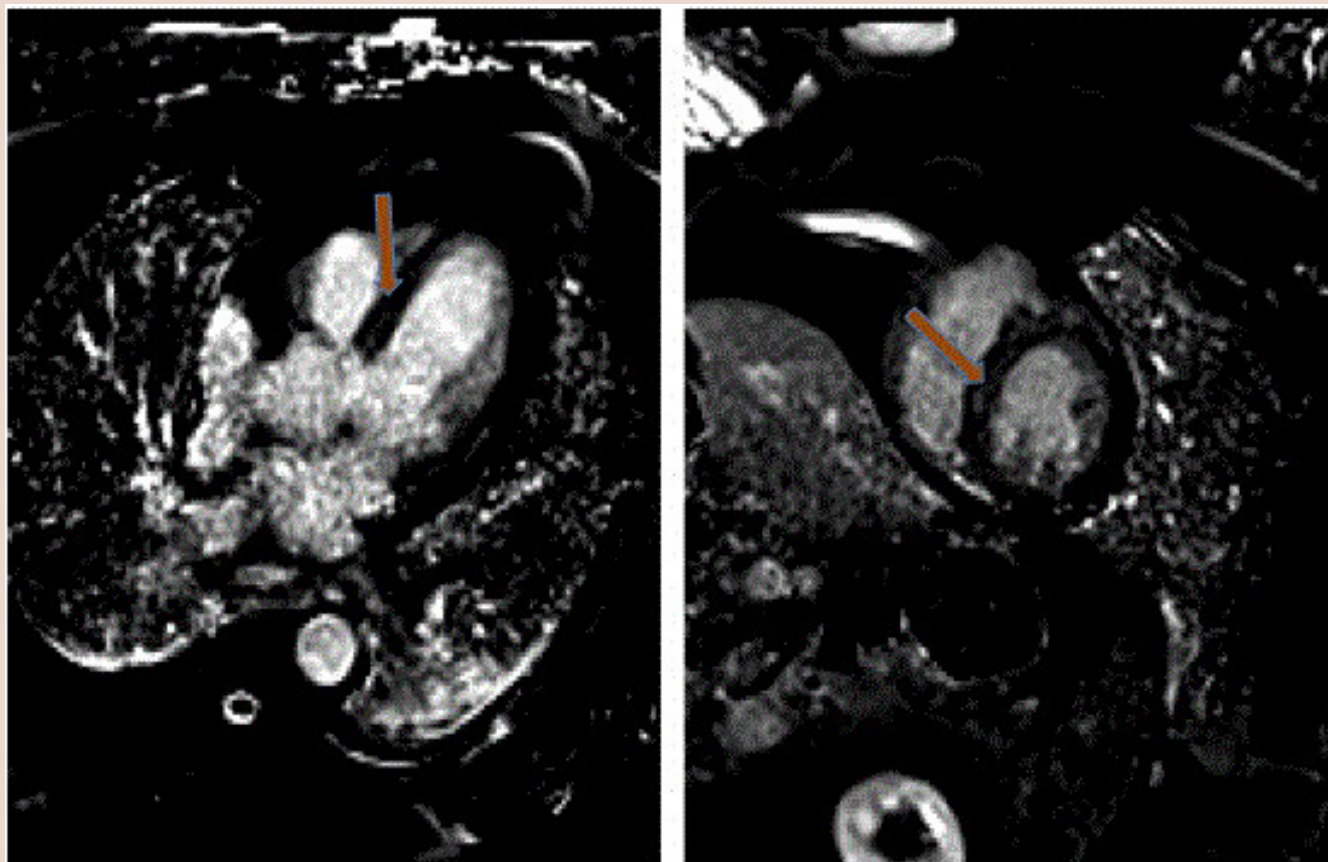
Cardiac Magnetic Resonance Imaging: Showing focal areas of subepicardial late gadolinium enhancement in the mid-to-basal anteroseptal and inferoseptal wall segments.
